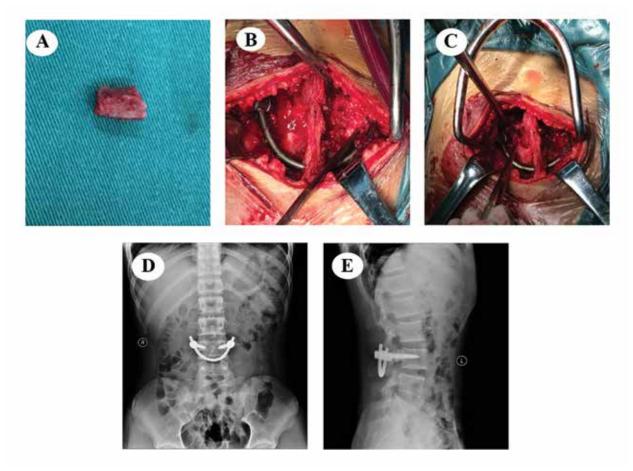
Operation process. U-rod inserted beneath the spinous process at the level of L3, and the iliac bones grafted at the bilateral pars (A, B, and C). Plain radiographs including anterior-posterior and lateral after the operation (D, E).
